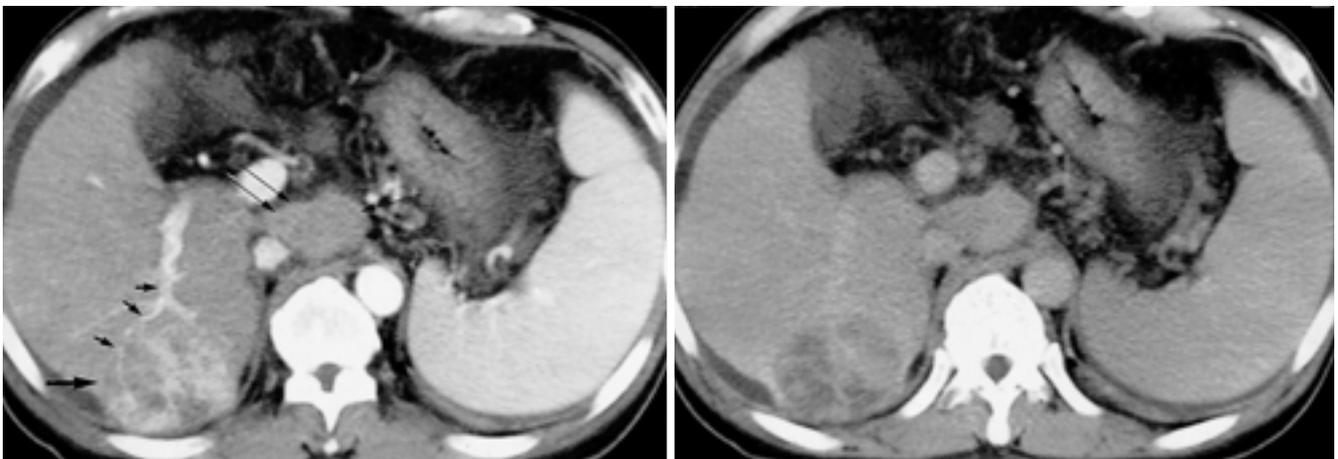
Secondary NHL in a 58-year-old man. Early phase CT(A) shows about 6cm sized heterogeneous enhanced mass(large arrow) in segment 6 of liver and associated lymph node enlargement(long arrows) in aortocaval area. Note that normal vascular structure passing through the mass(small arrows) is seen at the peripheral portion of the mass. Late phase CT(B) shows low attenuation mass.
